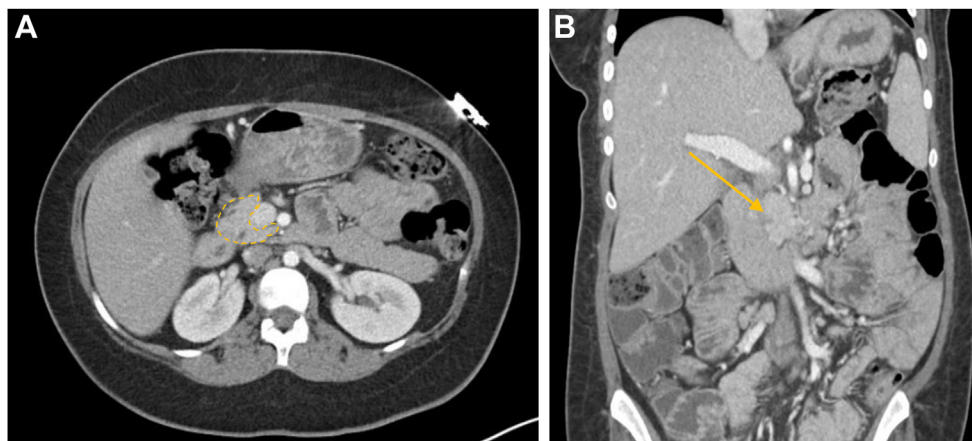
A, Computed tomography of abdomen: cross-sectional view showing the atrophy of pancreatic body and tail. B, Computed tomography of abdomen: coronal view showing the atrophy of pancreatic body and tail.
